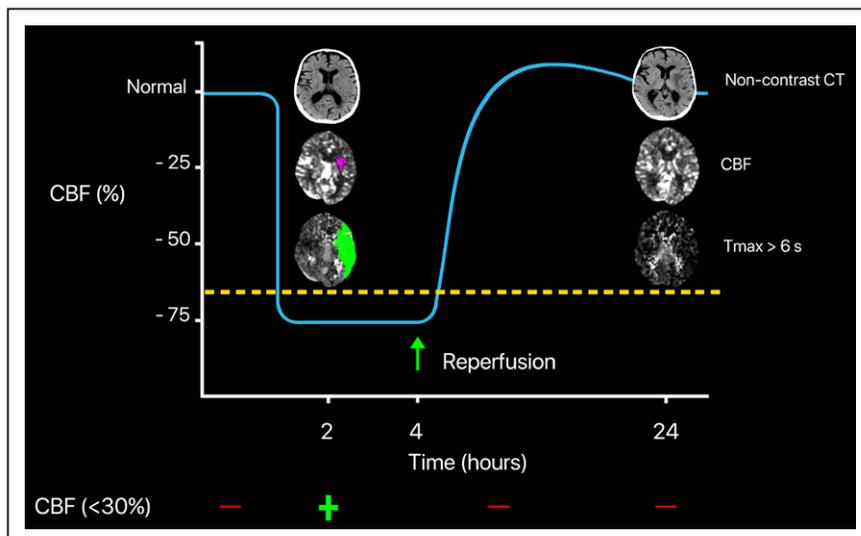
Patient with a left middle cerebral artery (MCA) occlusion. On the baseline scan, the noncontrast computed tomography (CT) is normal. There is a small, deep region in the brain that has low cerebral blood flow (CBF) and is identified in pink (which denotes that the CBF is <30% of normal). There is a large $T_{max} > 6$ s region, shown in green, reflecting the delayed arrival of the contrast agent in the MCA territory. After thrombectomy, there is a substantial increase in the CBF. The green $T_{max} > 6$ s lesion disappears and so does the pink CBF lesion; although the tissue is irreversibly injured, there is still blood flow in the irreversibly injured region after reperfusion. Therefore, the ischemic core is no longer visible on the CBF map obtained 24 hours after reperfusion.
